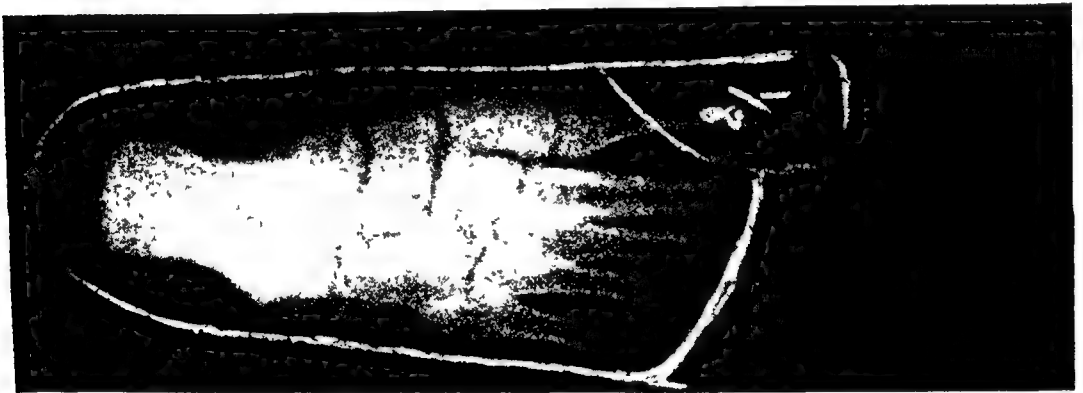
RADIOGRAPHIC CHART FOR COMPENSATING INSOLE (D J Morton principle)
